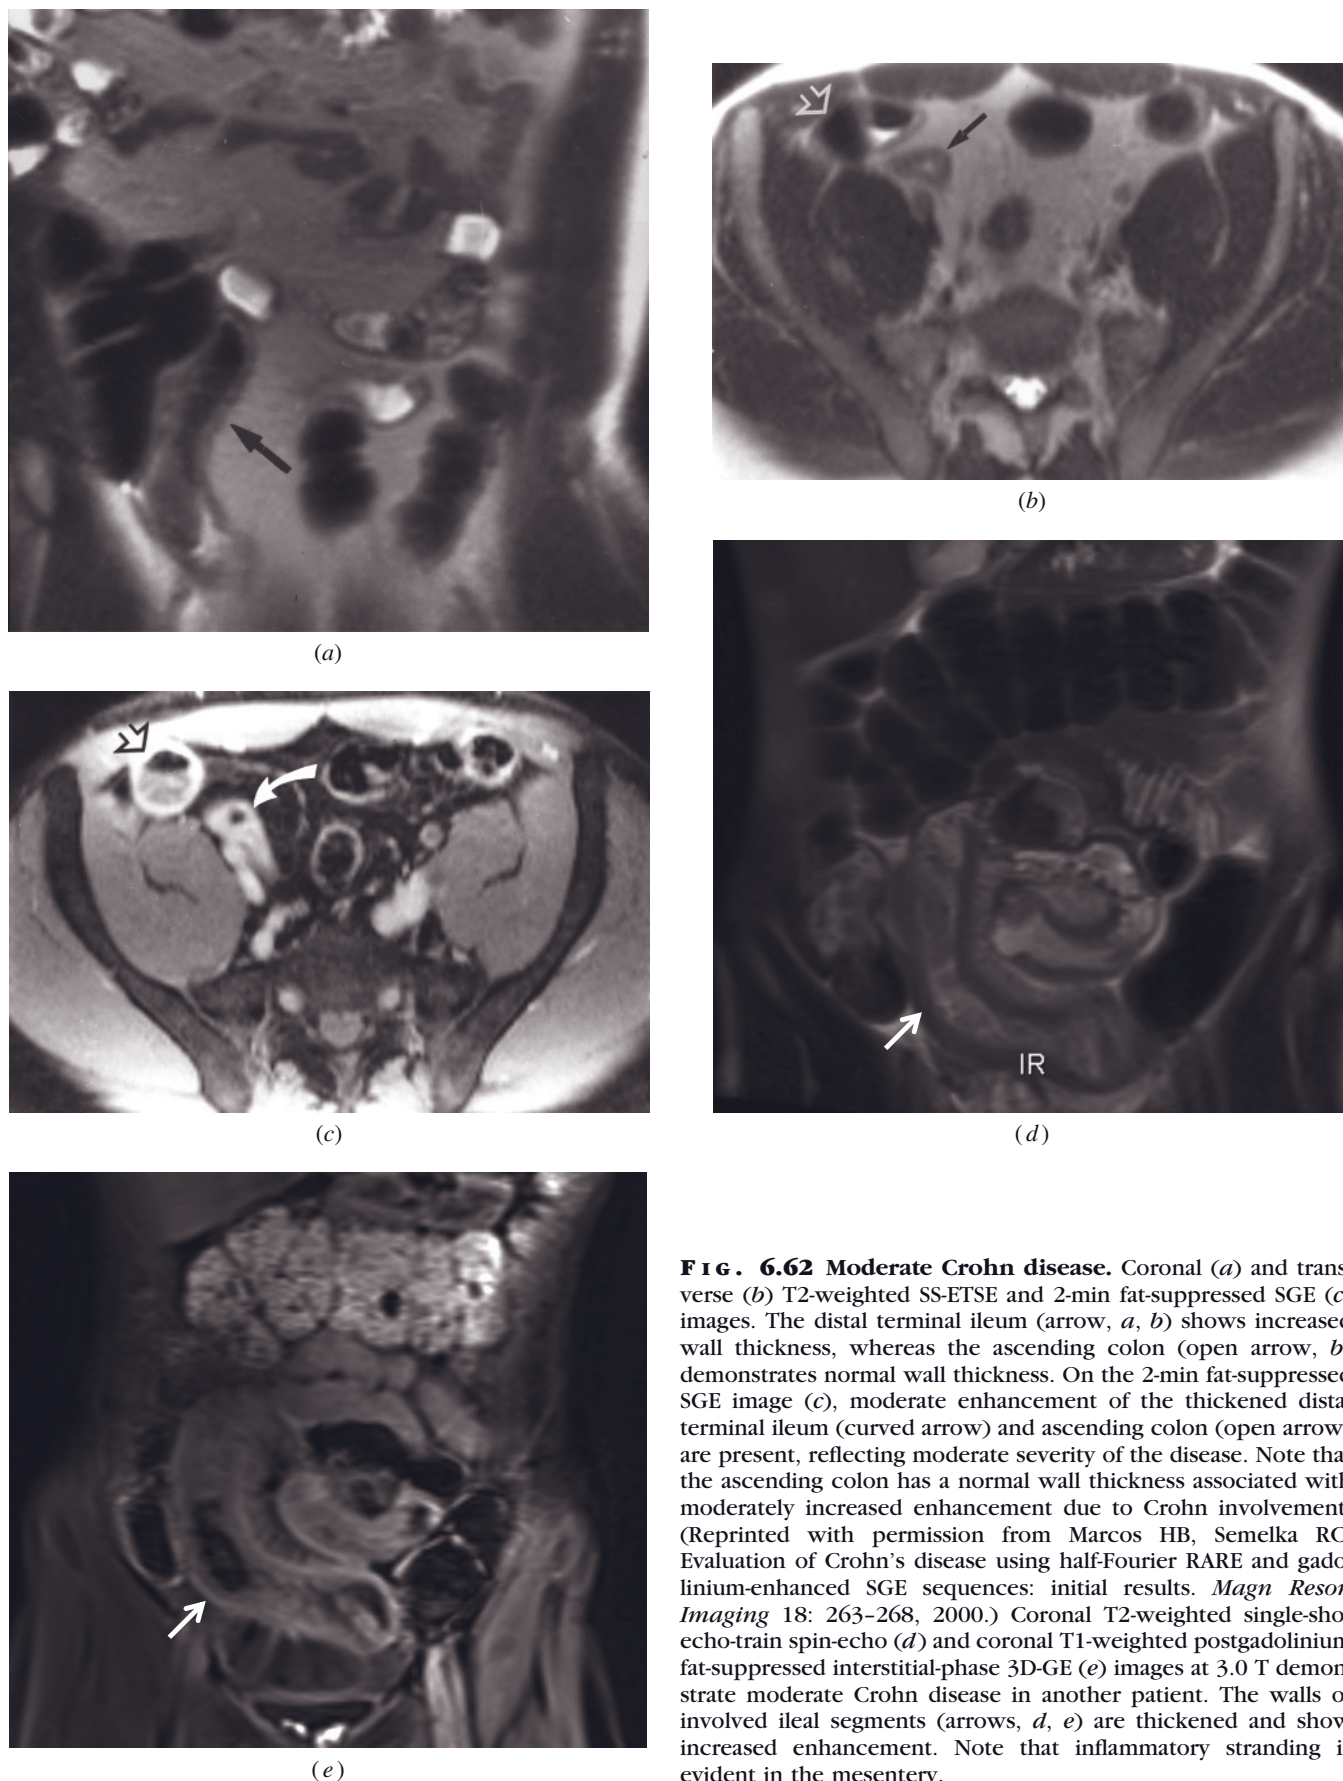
Moderate Crohn disease. Coronal (a) and transverse (b) T2-weighted SS-ETSE and 2-min fat-suppressed SGE (c) images. The distal terminal ileum (arrow, a, b) shows increased wall thickness, whereas the ascending colon (open arrow, b) demonstrates normal wall thickness. On the 2-min fat-suppressed SGE image (c), moderate enhancement of the thickened distal terminal ileum (curved arrow) and ascending colon (open arrow) are present, reflecting moderate severity of the disease. Note that the ascending colon has a normal wall thickness associated with moderately increased enhancement due to Crohn involvement. (Reprinted with permission from Marcos HB, Semelka RC: Evaluation of Crohn's disease using half-Fourier RARE and gadolinium-enhanced SGE sequences: initial results. *Magn Reson Imaging* 18: 263-268, 2000.) Coronal T2-weighted single-shot echo-train spin-echo (d) and coronal T1-weighted postgadolinium fat-suppressed interstitial-phase 3D-GE (e) images at 3.0 T demonstrate moderate Crohn disease in another patient. The walls of involved ileal segments (arrows, d, e) are thickened and show increased enhancement. Note that inflammatory stranding is evident in the mesentery.
